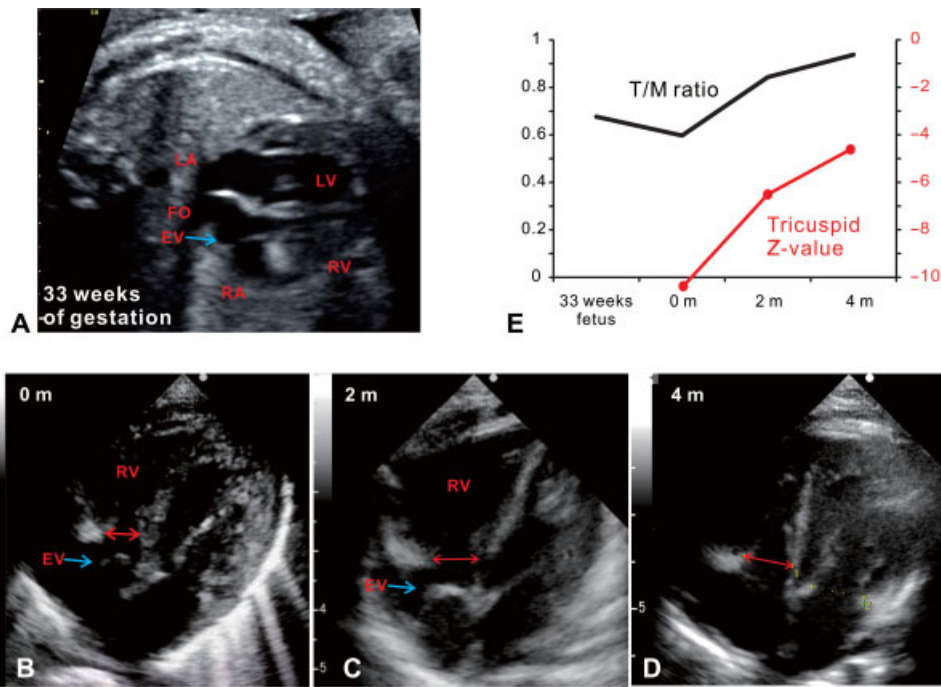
Hypoplastic right ventricle and tricuspid valve and postnatal amelioration in a patient with a large Eustachian valve. The tricuspid valve and right ventricle approached normal sizes after birth. (A) Fetal echocardiography at 33 weeks of gestational age. Abnormally, the right ventricle is significantly smaller than the left ventricle (6.7 mm tricuspid valve diameter, 9.9 mm mitral valve diameter, and 0.68 tricuspid to mitral valve diameter [T/M] ratio). (B) Echocardiography at 0 months (4.9 mm tricuspid diameter, 8.2 mm mitral valve diameter, and 0.60 T/M ratio). (C) Echocardiography at 2 months (8.1 mm tricuspid diameter, 9.6 mm mitral valve diameter, and 0.84 T/M ratio). (D) Echocardiography at 4 months (10.5 mm tricuspid diameter, 11.2 mm mitral valve diameter, and 0.93 T/M ratio). (E) Change in T/M ratio and tricuspid valve Z-value.^{6,7} The T/M ratio and tricuspid valve Z-value were very small at birth and subsequently increased. LA, left atrium; LV, left ventricle; FO, foramen ovale; EV, Eustachian valve; RA, right atrium; RV, right ventricle.
